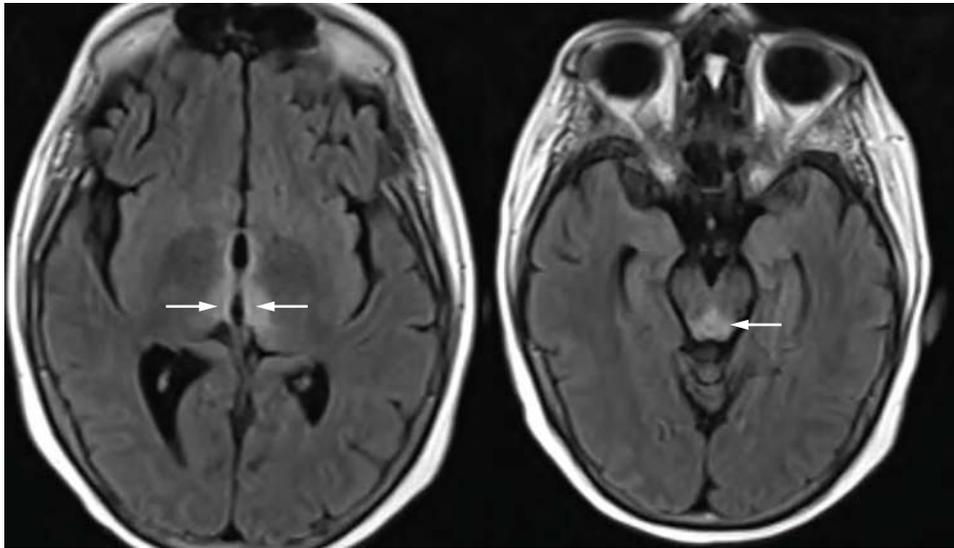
Wernicke encephalopathy. FLAIR MR images show hyperintensity in the medial thalami and periaqueductal gray matter (*white arrows*) in this patient presenting with altered mental status and oculomotor dysfunction.
